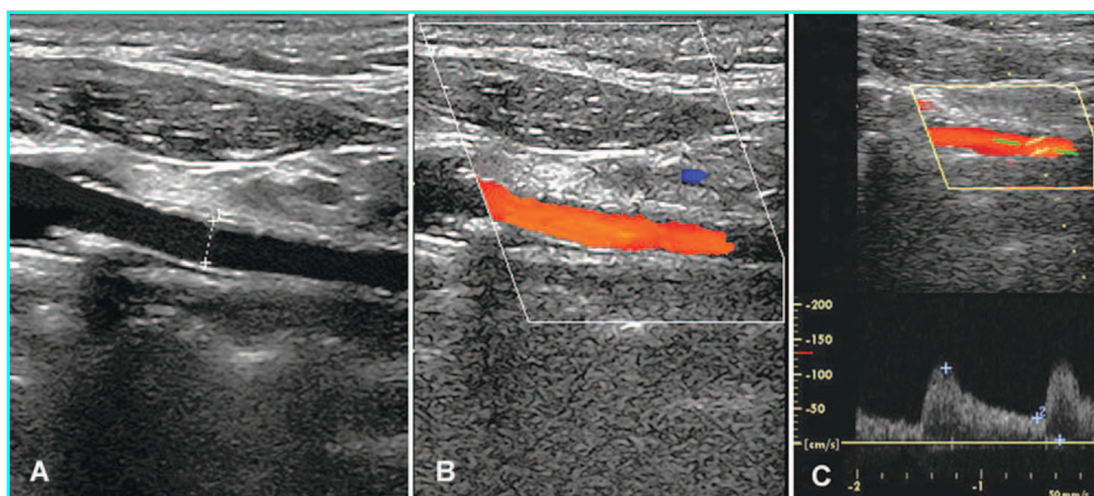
A,B,C – DES 5 years after insertion – Doppler aspect.
